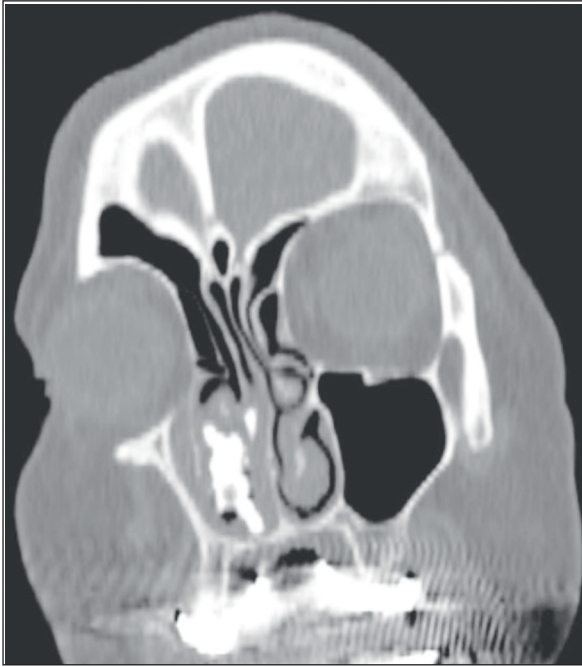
Coronal section computed tomography image of a mass containing widespread foci of calcification almost entirely filling the right nasal cavity.
